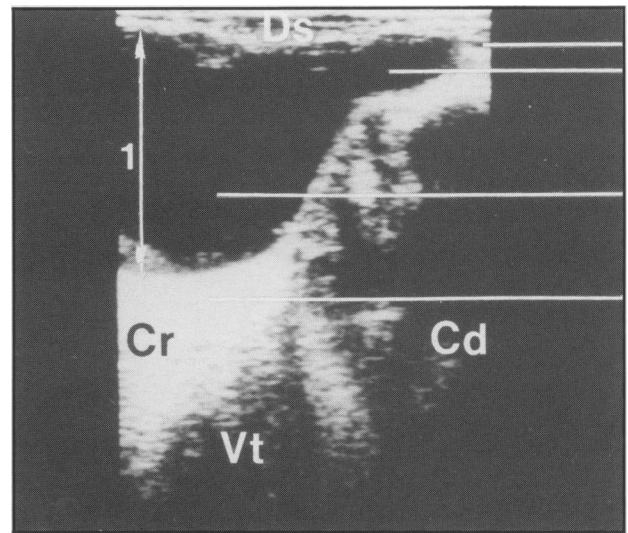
Ultrasonogram of a longitudinal section through the urinary bladder obtained transrectally with a 5.0-MHz linear rectal transducer. Top line = partially visible urethral lumen; second line = neck of the urinary bladder; third line = urinary bladder; bottom line = posterior enhancement; Ds = dorsal; Vt = ventral; Cd = caudal; 1 = diameter of the urinary bladder.
